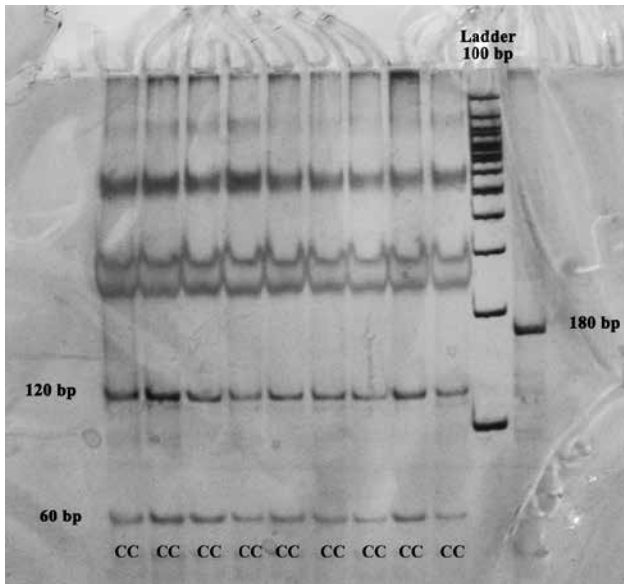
Representative screening for the endothelial nitric oxide synthase C786T polymorphism; 180-bp band, genotype TT; 120 & 60-bp band, genotype CC; 180, 120 & 60-bp bands, genotype CT
